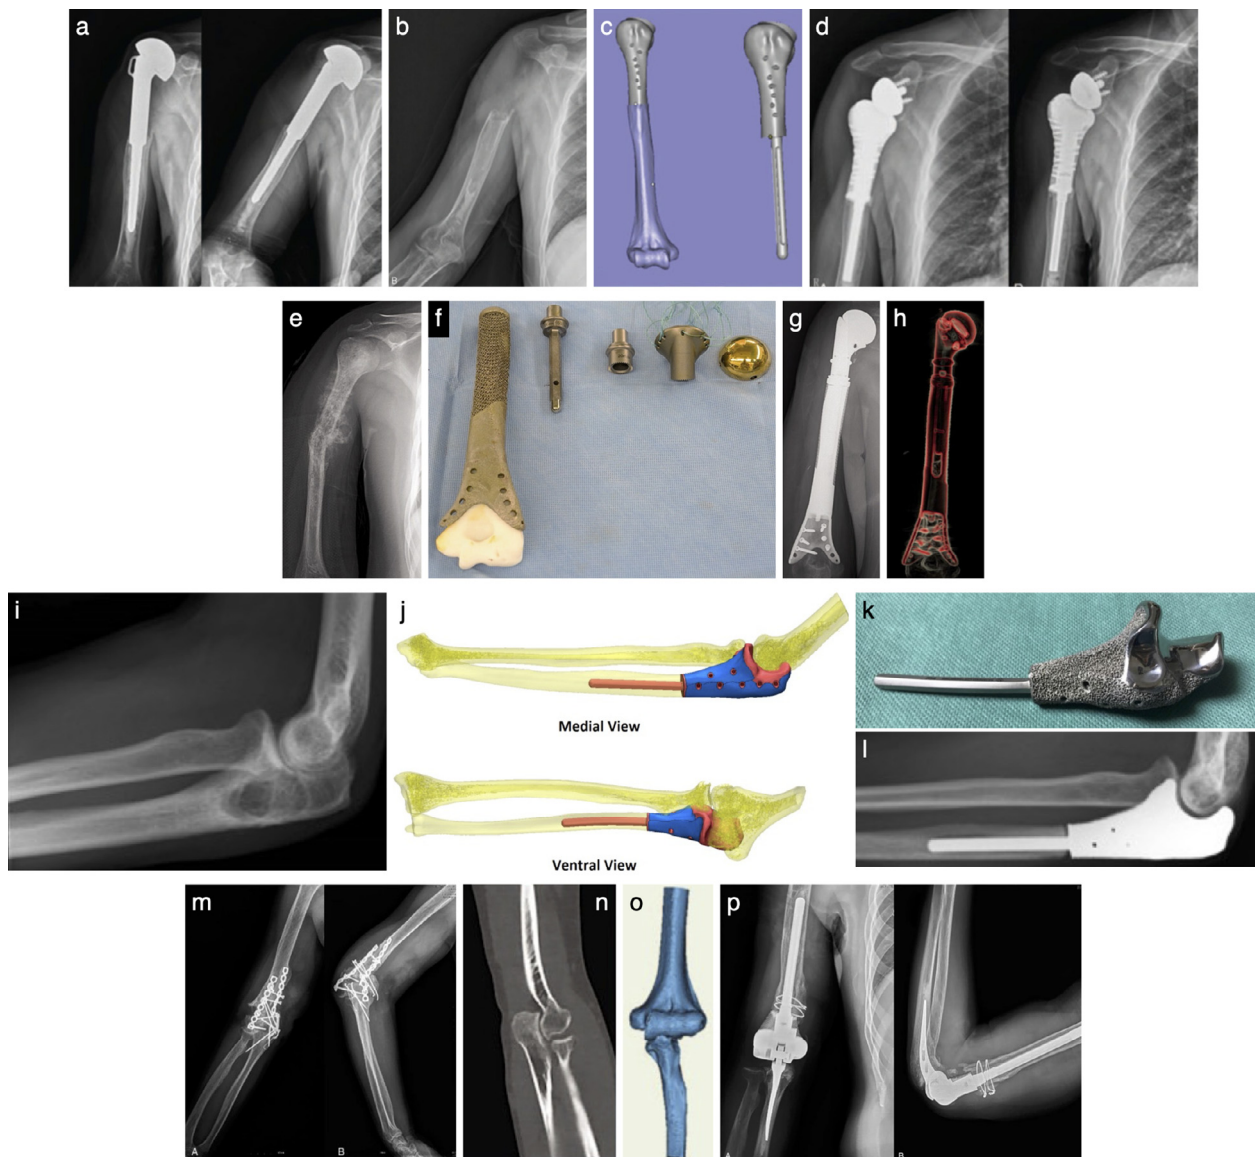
(a–d) Chondrosarcoma of the proximal humerus. (a) Previous humeral resection and total shoulder arthroplasty. Radiographs. (b) Removed failed previous prosthesis. Radiograph. (c) Prosthesis design. (d) Radiographs, 3-months (left) and 12-months (right) postoperatively. From Zou et al. 2018. Medicine (Baltimore). Reproduced under the terms of the CC BY-NC-ND 4.0 [81]. (e–h) Osteosarcoma of the humerus. (e) Radiograph, preoperative. (f) 3D printed prosthesis. (g) Radiograph, postoperative. (h) Computed tomography showing humeral reconstruction. From Park et al. 2020. Acta Orthop. Reproduced under the terms of the CC BY 4.0 [83]. (i–l) Grade II chondrosarcoma of the proximal ulna. (i) Radiograph, preoperative. (j) Designed prosthesis. (k) 3D printed prosthesis. (l) Radiograph, 30-months postoperatively. From Brandsma et al. 2020. JSES Int. Reproduced under the terms of the CC BY 4.0 [84]. (m–p) Comminuted distal humerus fracture. (m) Fixation failure and non-union after internal fixation. Radiographs. (n) Computed tomography of the intact contralateral limb. (o) Implant design based on mirrored images of the contralateral limb. (p) Radiographs, 36-months postoperatively. From Wu et al. 2020. Medicine (Baltimore). Reproduced under the terms of the CC BY 4.0 [85].
